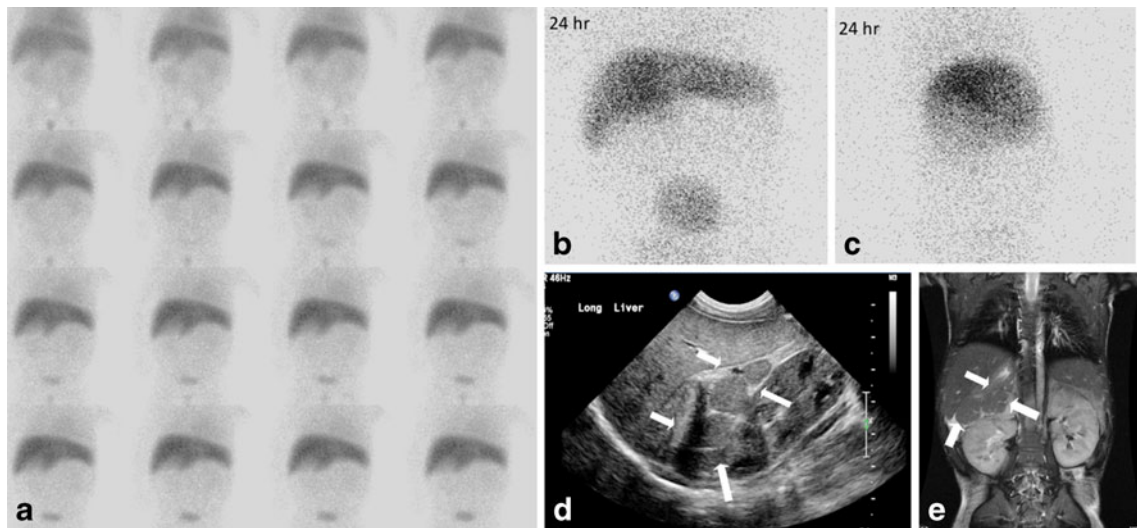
Conjugated hyperbilirubinemia in a 3-month-old full-term boy. a Sequential anterior abdominal images demonstrate normal hepatic uptake and no biliary excretion during the first hour of scanning. Note the transverse orientation of the liver. b, c Anterior and lateral scintigraphy images at 24 h post-injection do not demonstrate excretion. d Longitudinal
